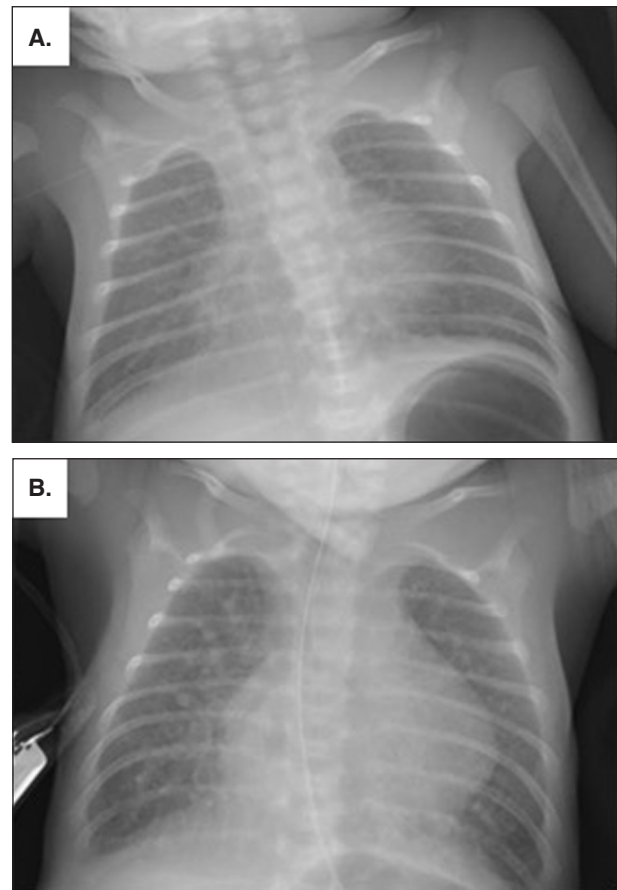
Chest X-ray. A. X-ray on the first day of life showing bilateral hypodiaphania. B. X-ray on the fourth day of life showing improvement in the pulmonary vascular weave and disappearance of the air bronchogram and cardiomegaly.
